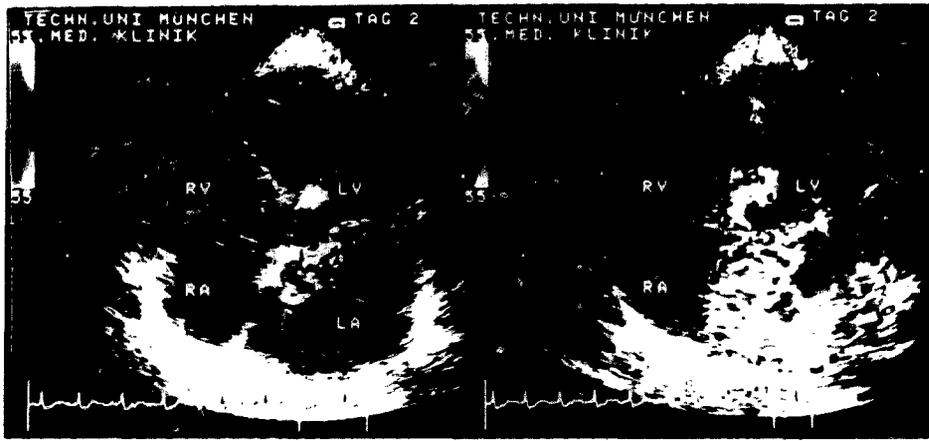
Original color Doppler recording in a patient with severe mitral regurgitation as a result of prolapse of the posterior leaflet. Note the complete display of the eccentric jet only on the right tracing with contrast enhancement. LA (RA) = left (right) atrium; LV (RV) = left (right) ventricle; TAG = day.
